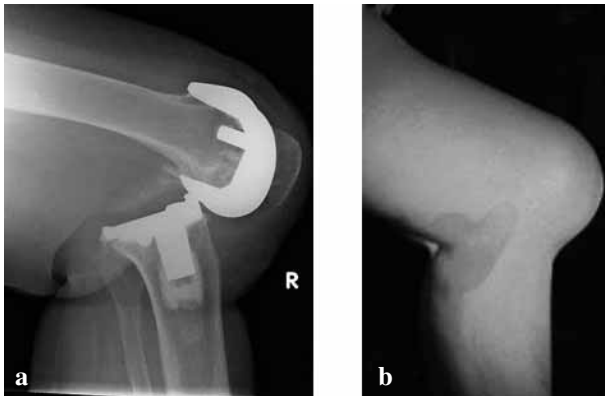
a. Lateral radiograph of the posteriorly dislocated TKA ; b. Clinical picture of the knee after TKA dislocation.
